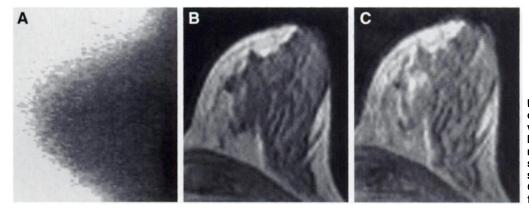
Proliferating fibrocystic disease. Previous mammographic readings were indeterminate due to dense fibroglandular parenchyma. (A) In scintimammography, no focal accumulation of sestamibi was observed. (B, C) MRI showed an irregular lesion with a high Gd-enhancement so MRI diagnosis was false-positive.
